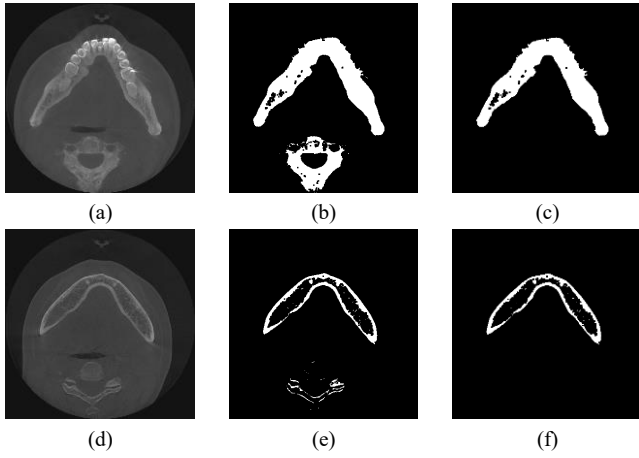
(a) Maximum intensity projection of the mandibular part of CBCT. (b) Binarized and morphologically closed image of (a). (c) Biggest connected component of (b) remained. (d) An automatically selected slice that contains mandible. (e) Binarized and morphologically closed image of (d). (f) Only mandible part remained.
